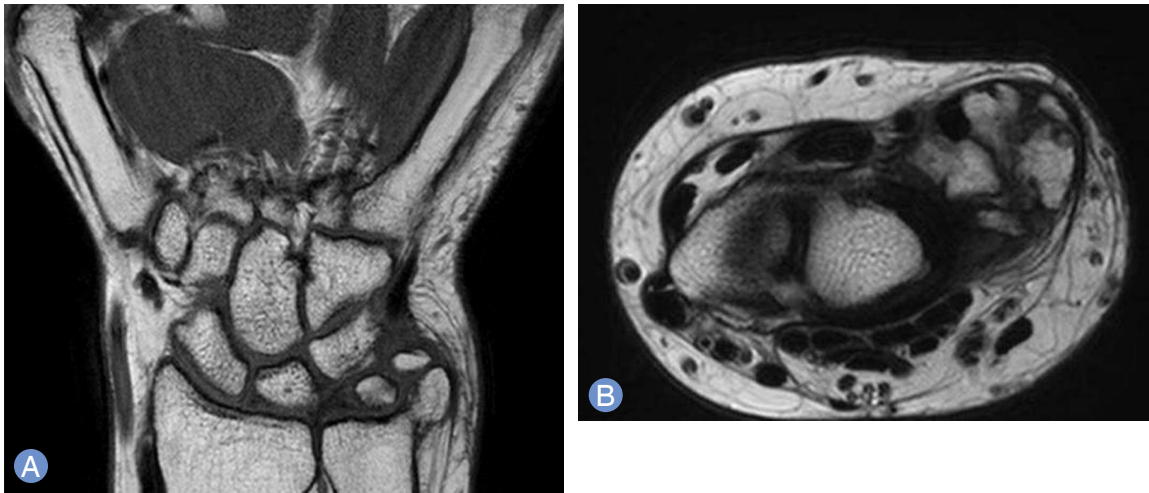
T1-weighted coronal (A) and axial (B) images showing loose bodies in the ulnocarpal joint.
